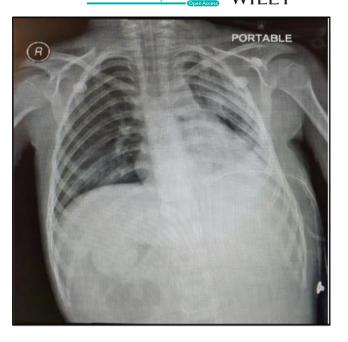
Postoperative chest radiograph demonstrates patchy consolidation in the smaller left lung, with a chest tube present on that side obscuring the costophrenic angle. The mediastinum is centrally located, and the right lung appears normal in size.
